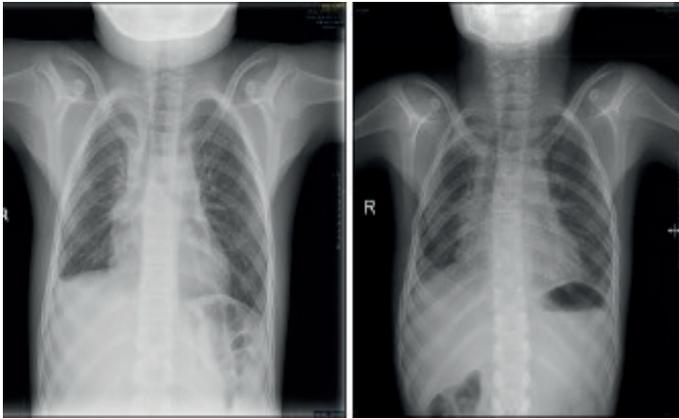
Chest X-ray at the first admission (before the nintedanib treatment: on the right side; 6th months of nintedanib treatment: on the left side)
